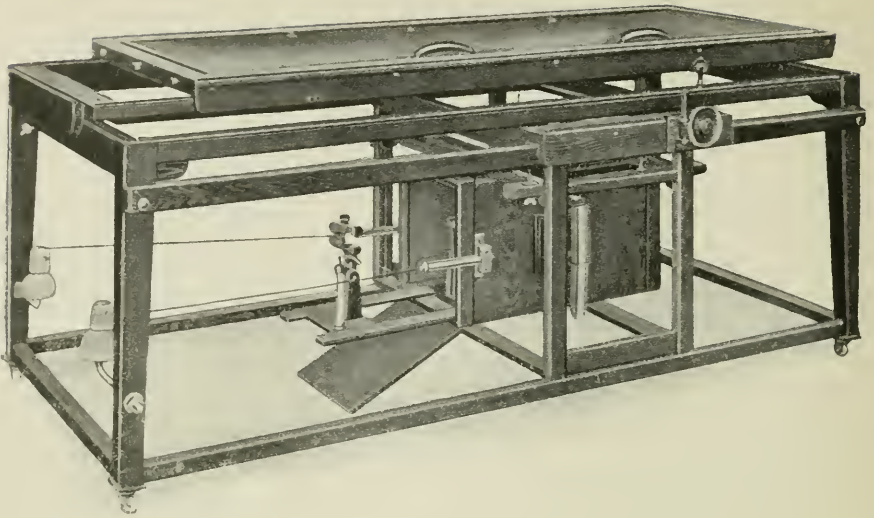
A convenient form of X-ray couch. (Siemens.)
